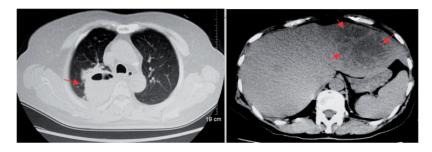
Head and lung computed tomography revealed that the density of the upper lobe of the right lung was increased, with cavities and fluid visible in the upper lobe, indicating potential abscess, and assessment of the left liver lobe revealed multiple low-density shadows, suggesting liver abscess.
